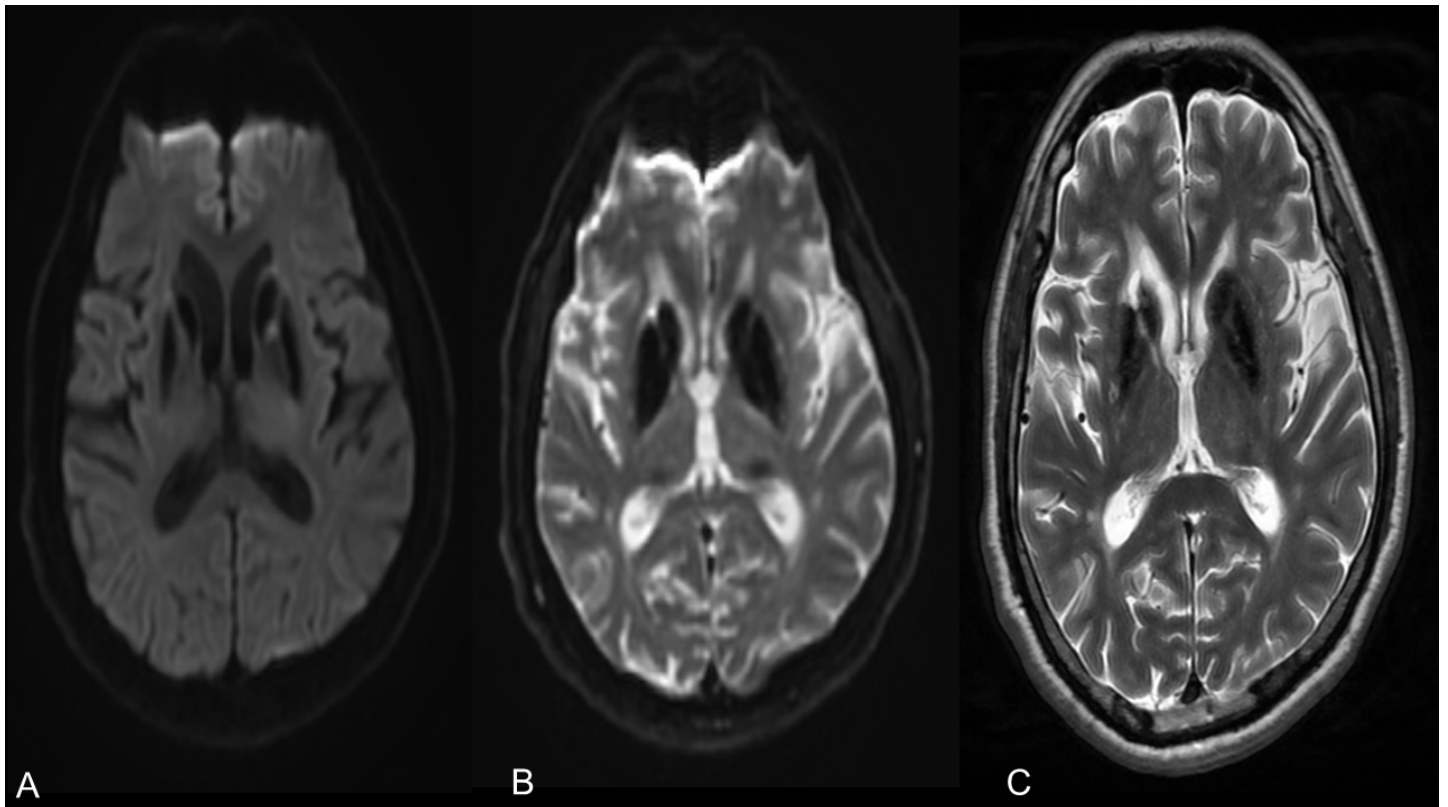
Brain MRI showing symmetric calcifications. (A) Diffusion-weighted image, and (B) apparent diffusion coefficient map with low signal intensity in both basal ganglia, but no restricted diffusion. (C) T2-weighted image with low signal intensity in both basal ganglia.
